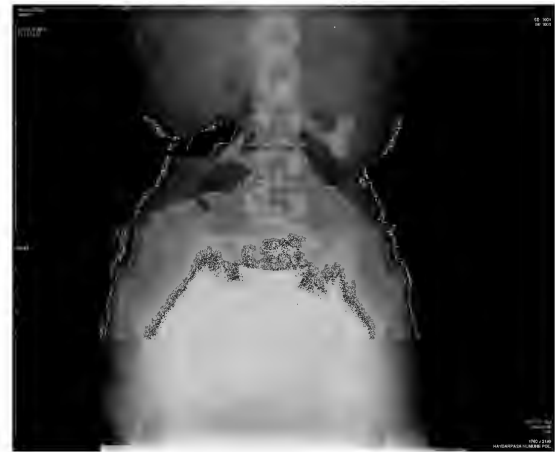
Upright abdominal radiography shows multiple air- fluid levels.
